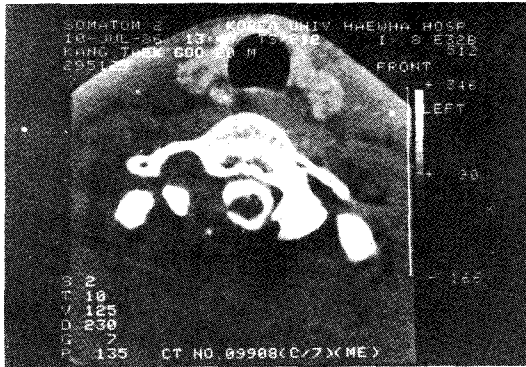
3 months follow-up spinal CT scan after completion of postoperative RT : there is no evidence of tumor growth and no evidence of cord deviation.
